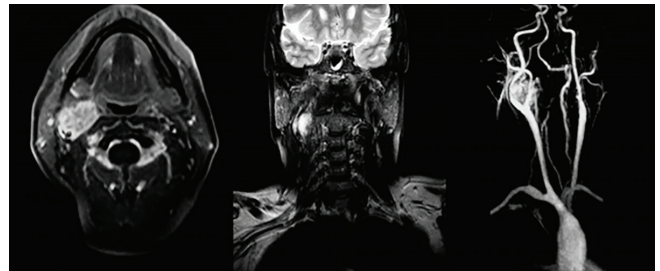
MRI axial, coronal and MRA images: High signal tumor with characteristic salt and pepper image from the dilatation of intermediate signal vessels in the lesion content
